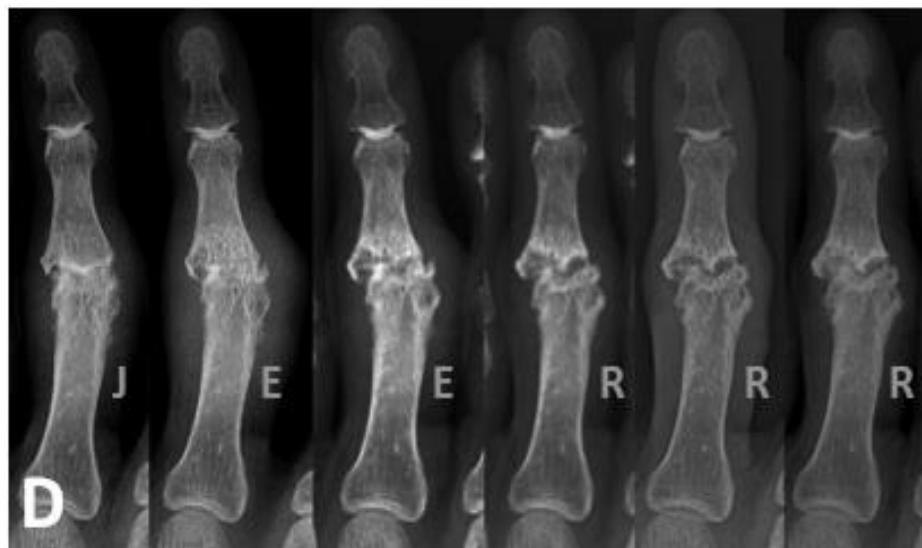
radiographic progression of a proximal IP joint from 'J' phase with loss of joint space to the 'E' phase with osteolytic activity in the subchondral bone area, and final remodeling of the destroyed tissues (R). Radiographs were taken with 6-months interval.
